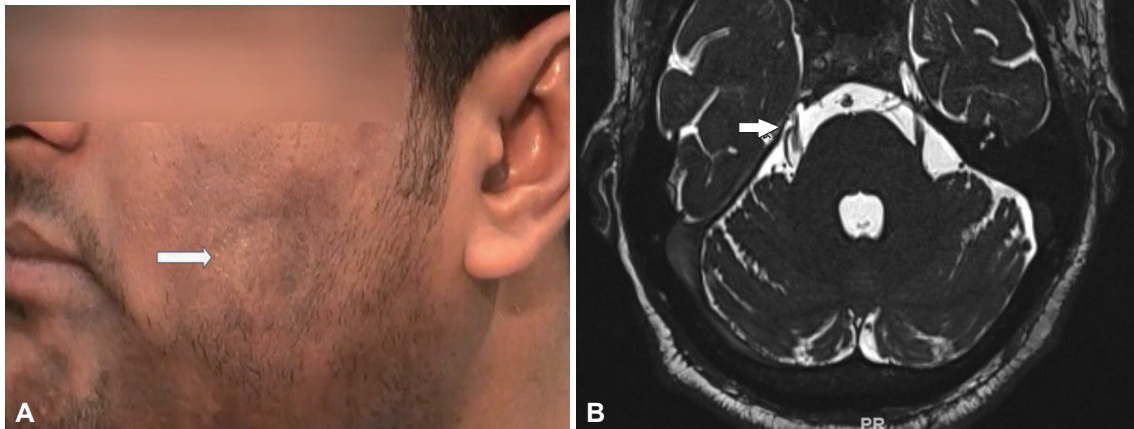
Clinical and radiological features of hemimasticatory spasm. A: Morphea (arrow) on the left cheek of Patient 1. B: MRI (cis 3D sequence) shows a vascular loop (superior cerebellar artery, arrow) around the right trigeminal nerve of Patient 3.
